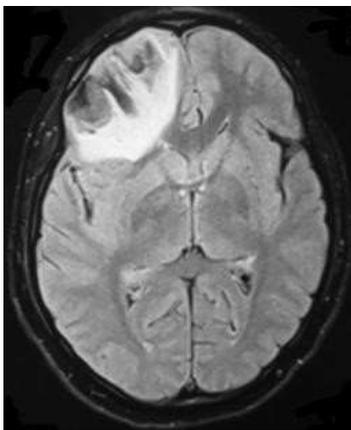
T1 weighted MRI brain showing right frontal hyper intense lesion with haemorrhage.
